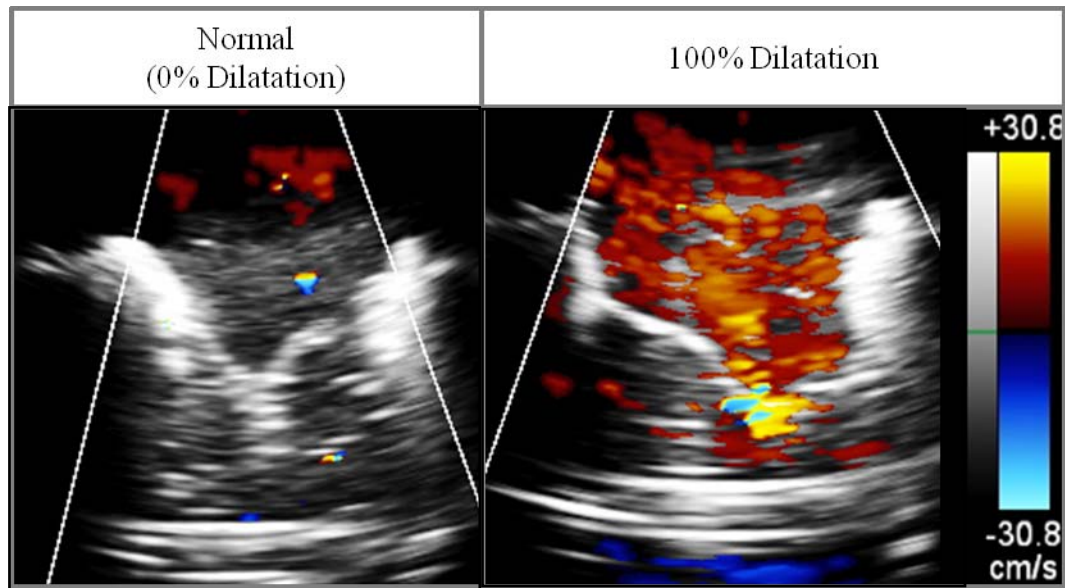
Color Doppler images of a valve with a normal annulus area and 100% dilated annulus. A central regurgitant jet is visible with 100% dilatation (click images for videos).
